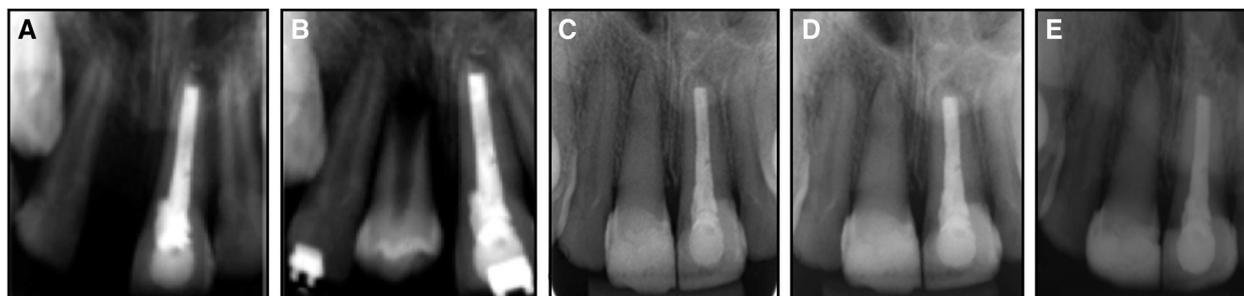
Periapical radiographs from pretreatment to 9 years posttreatment: A, initial radiography; B, immediately after autotransplantation surgery; C, 1-year follow-up (beginning of orthodontic treatment); D, 5-year follow-up (orthodontic treatment completion); E, 9-year follow-up.
